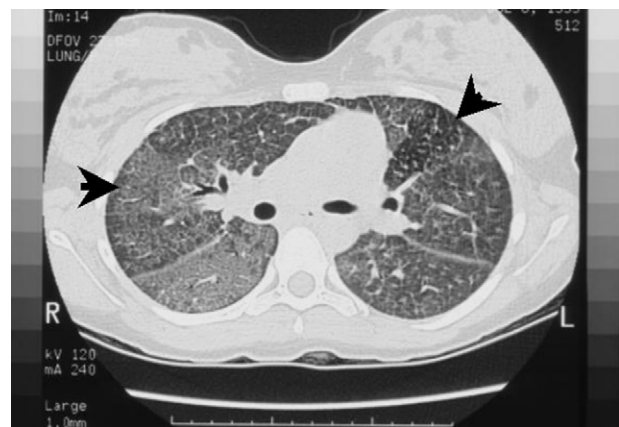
Early changes of bronchiolitis obliterans as seen on a high-resolution CT scan. Note the changes consistent with mosaic perfusion (see arrows), characterized by areas of varying density (differing attenuation).
